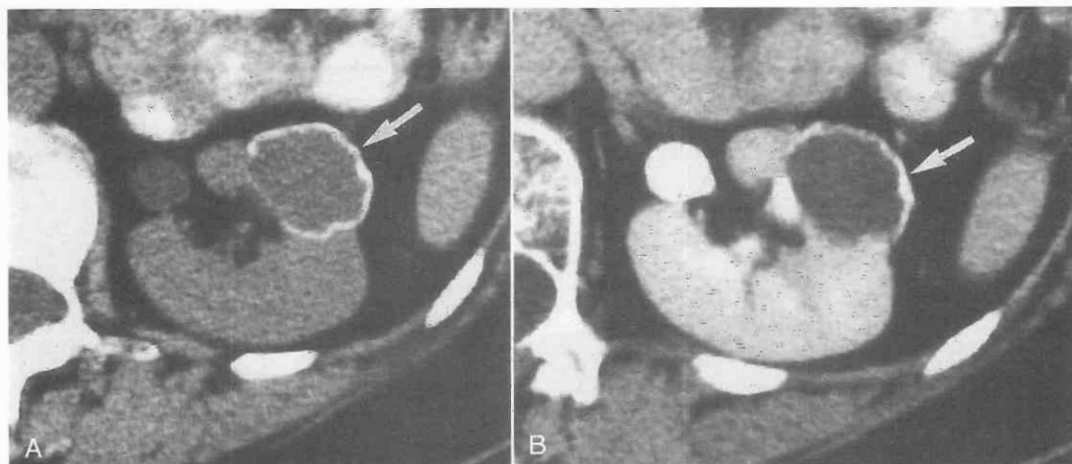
Hemorrhagic benign renal cyst; category III lesion. The lesion (arrow) shows thick, irregular mural calcification. The lesion has an attenuation value of 12 HU on an unenhanced CT scan (A) and shows no enhancement after contrast administration (B). The kidney was explored, and a local resection of the lesion was performed.
